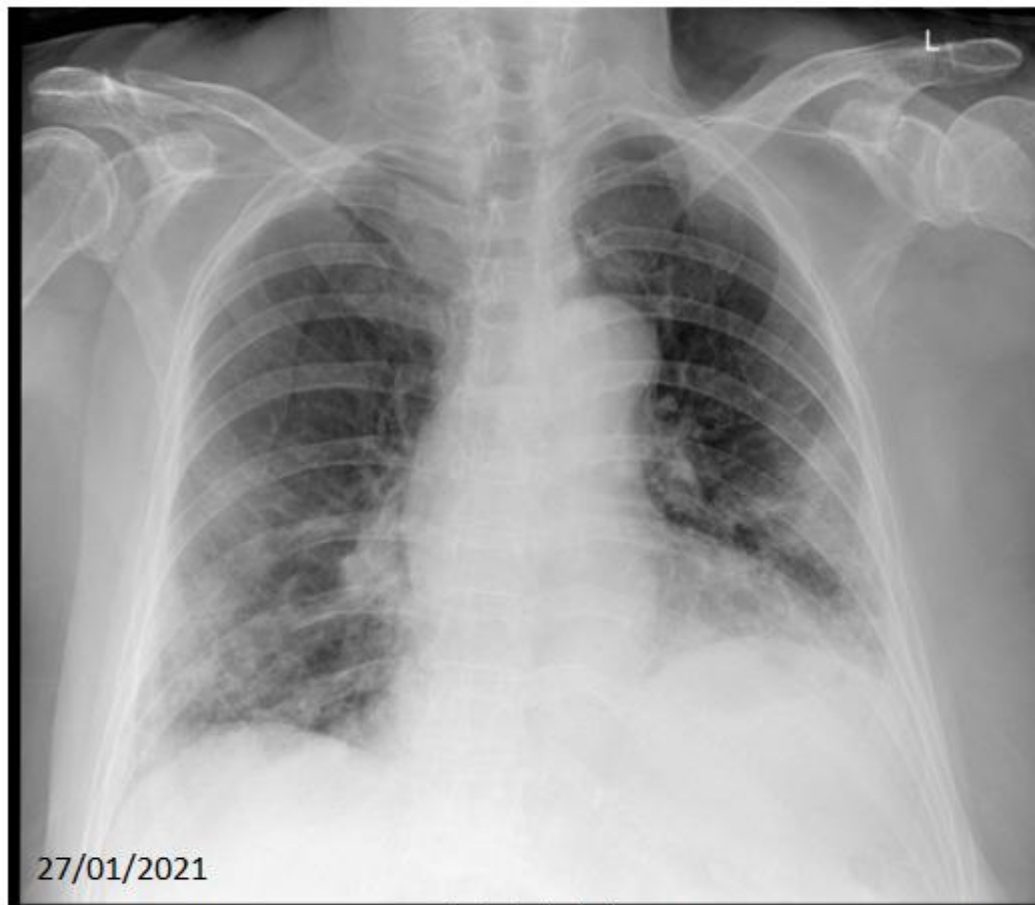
Chest Xray upon admission shows bilateral peripheral ill-defined opacities, more prominent in the lower zones.
